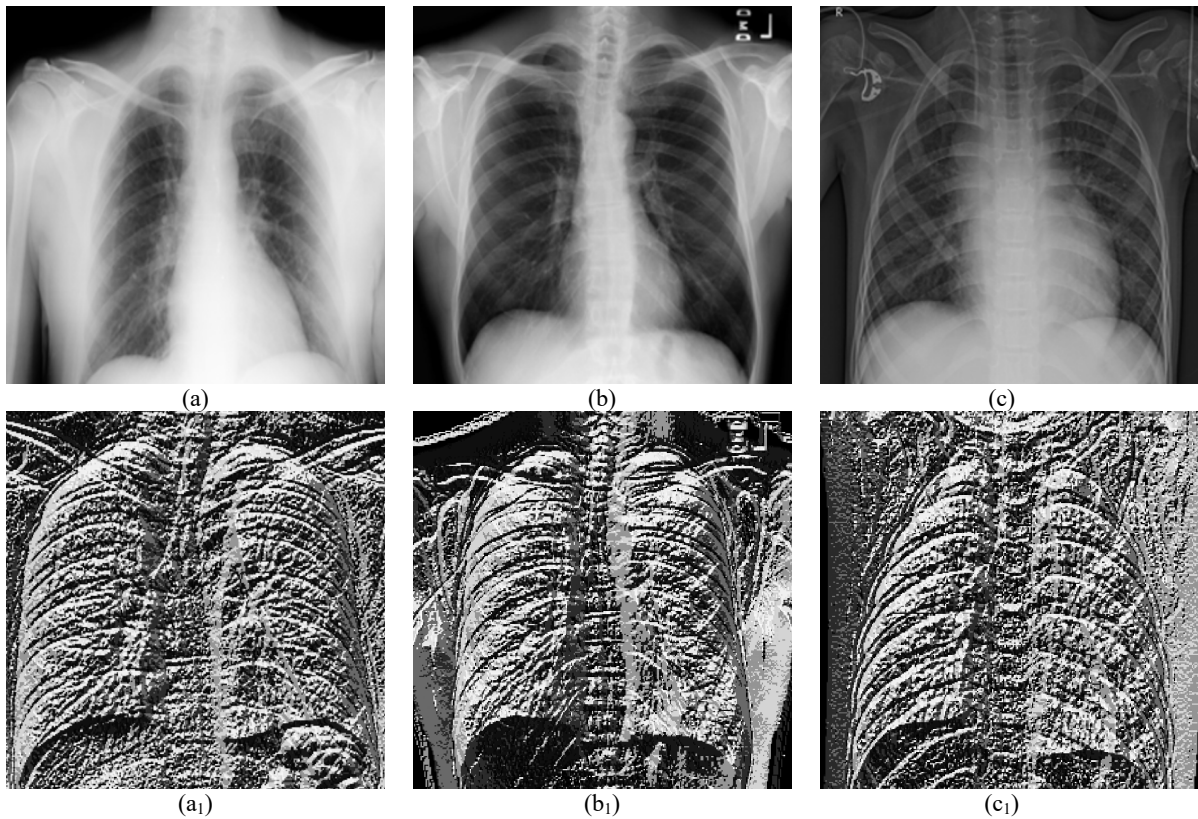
The original images of COVID-19 (a), Normal (b), and Viral Pneumonia (c) X-ray images and the feature images of these images obtained by applying LBP are (a₁), (b₁), and (c₁), respectively.
